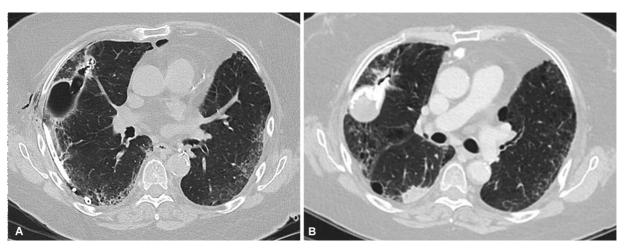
Computed tomography (CT) chest axial images (A) prior to repeat glue embolization (B) 13 months postprocedure showing the cavity adjacent to glue embolization filling with fluid over time and stable in appearance.
